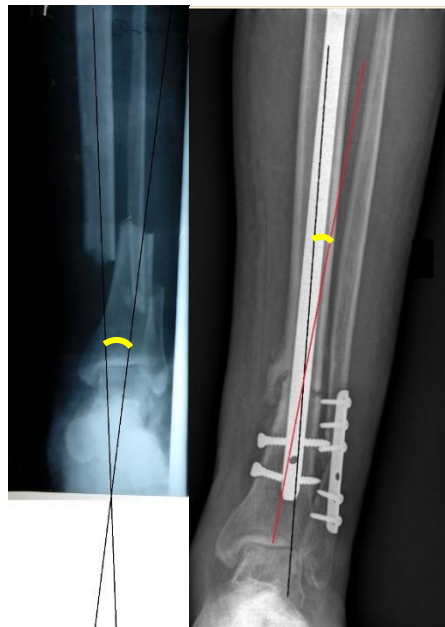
4 weeks post operative radiograph
